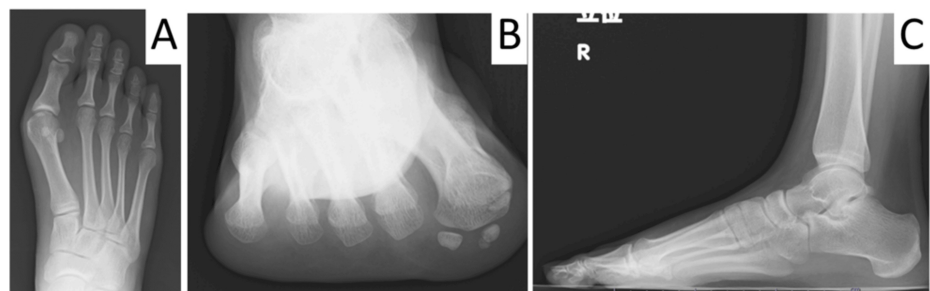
Preoperative X-ray findings of the right foot and ankle
